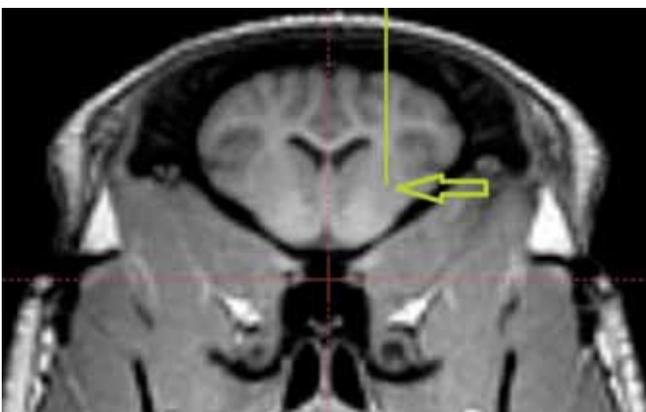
shows the stereotaxic MRI loaded into the coordinate calculating system. The arrow points toward the target, which in this case is the right putamen. The retrograde tracer FluroGold was injected to visualise the afferent connections of this striatal structure. The vertical green line indicates the injection tract.
